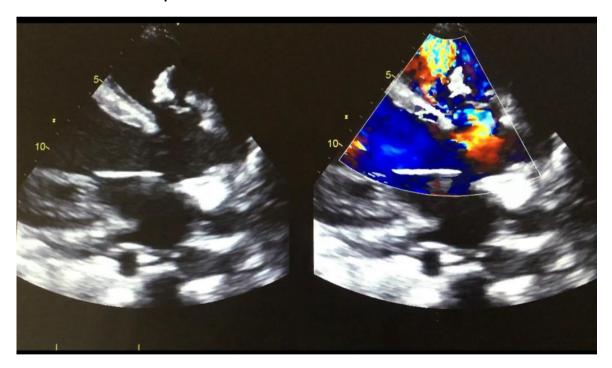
Long axis parasternal echocardiographic section showing perimembranous interventricular communication with vegetation inserted on its edges
